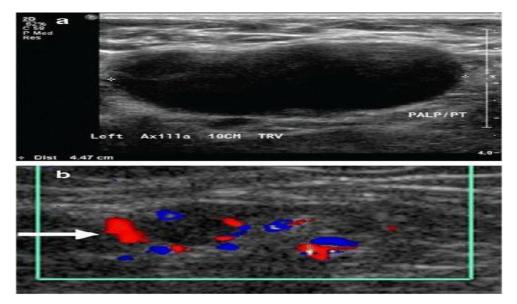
Fig showing abnormal lymph nodes: characteristics concerning for malignancy: a. absence of the fatty hilum and b. increased focal cortical thickness greater than 3 mm with colour Doppler US that shows hyperaemic blood flow in the hilum and central cortex or abnormal (non-hilar cortical) blood flow.
